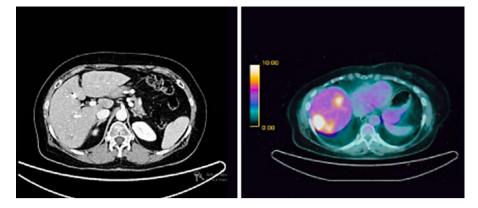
PET-CT (August 2014) shows multiple liver lesions, the biggest measuring 39 mm, in the right liver (SUV max. 17.5).
